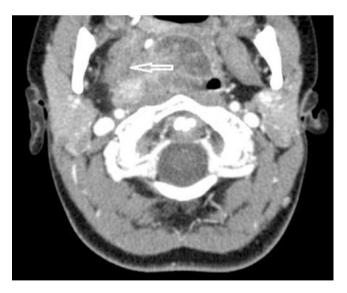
Contrast-enhanced axial CT shows large obstructive mildly enhancing heterogeneous mass in oronasopharynx. Note loss of fat space definition of pterygoid muscle on the right side (arrow)
